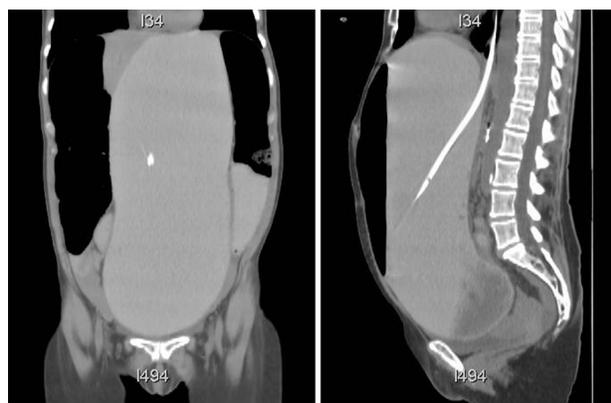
Massive gastric distention shown on CT.
